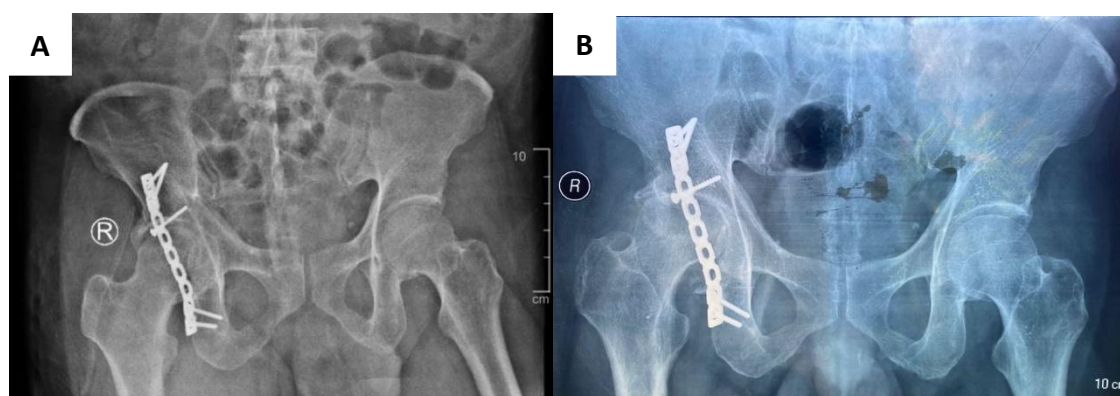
A. Pelvis AP X-ray post-ORIF, B. AVN right hip in pelvis AP X-ray after internal fixation within three months
